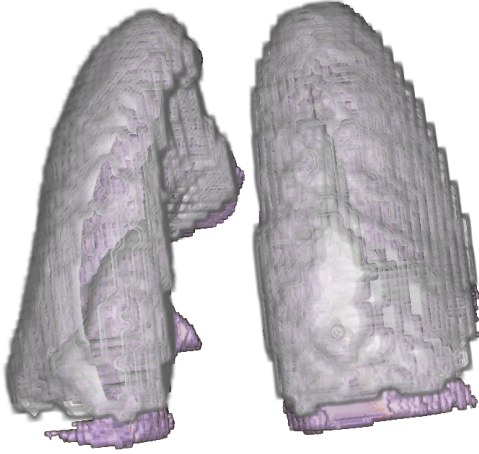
3D models of segmented SPECT and CT overlaying
